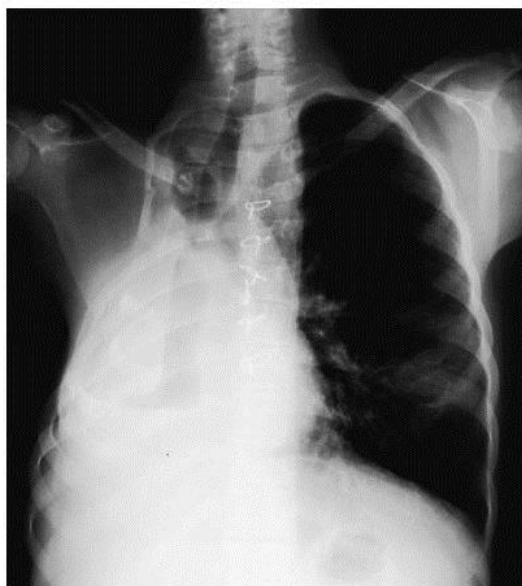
Chest radiograph demonstrates the sternotomy wire sutures, thoracic deformity and volume loss due to the previous surgery. The mediastinum is deviated to the right and there is air within the right hemithorax, indicating an air leak.
